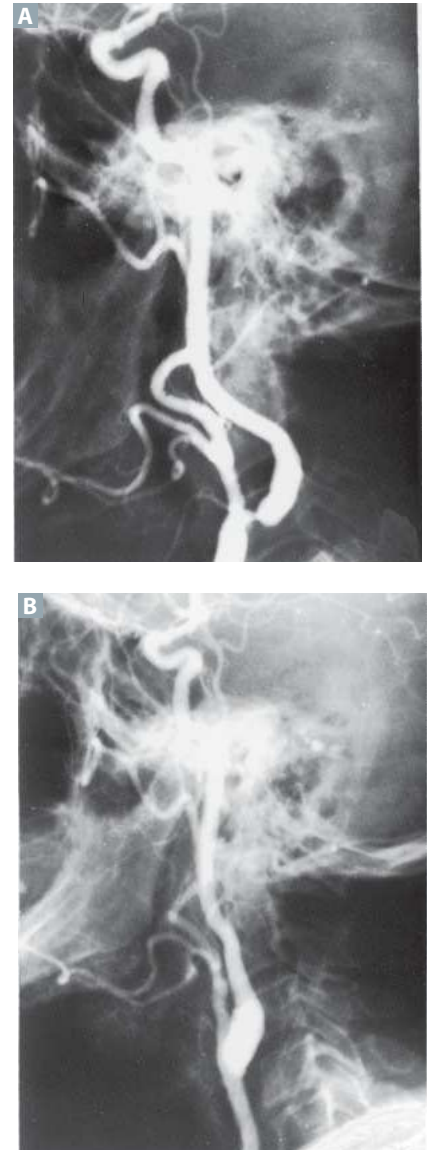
Vascular studies preendarterectomy and postendarterectomy. (A) Carotid arteriogram showing stenosis of the proximal internal carotid artery. (B) Postoperative arteriogram with restoration of the normal luminal size following endarterectomy. (Reproduced with permission from Way LW. *Current Surgical Diagnosis & Treatment*. 10th ed. Stamford, CT: Appleton & Lange; 1994.)
